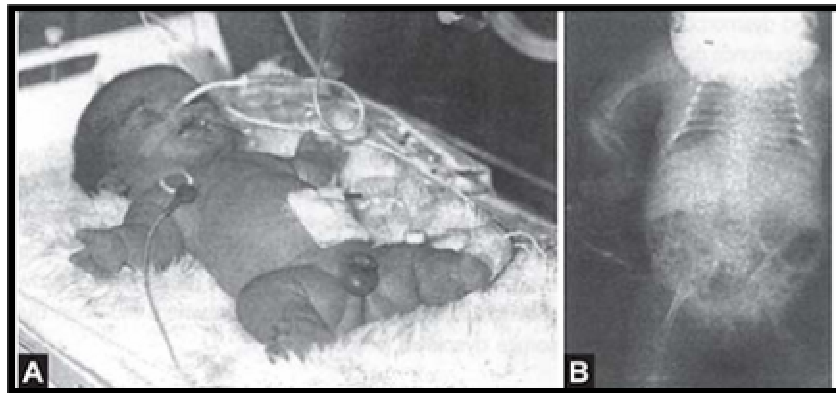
(A) Skeletal dysplasia in a new born (B) X-rays of the same infant showing shortening of the long bones and narrow thoracic cavity (*Purandarey, 2009*).
